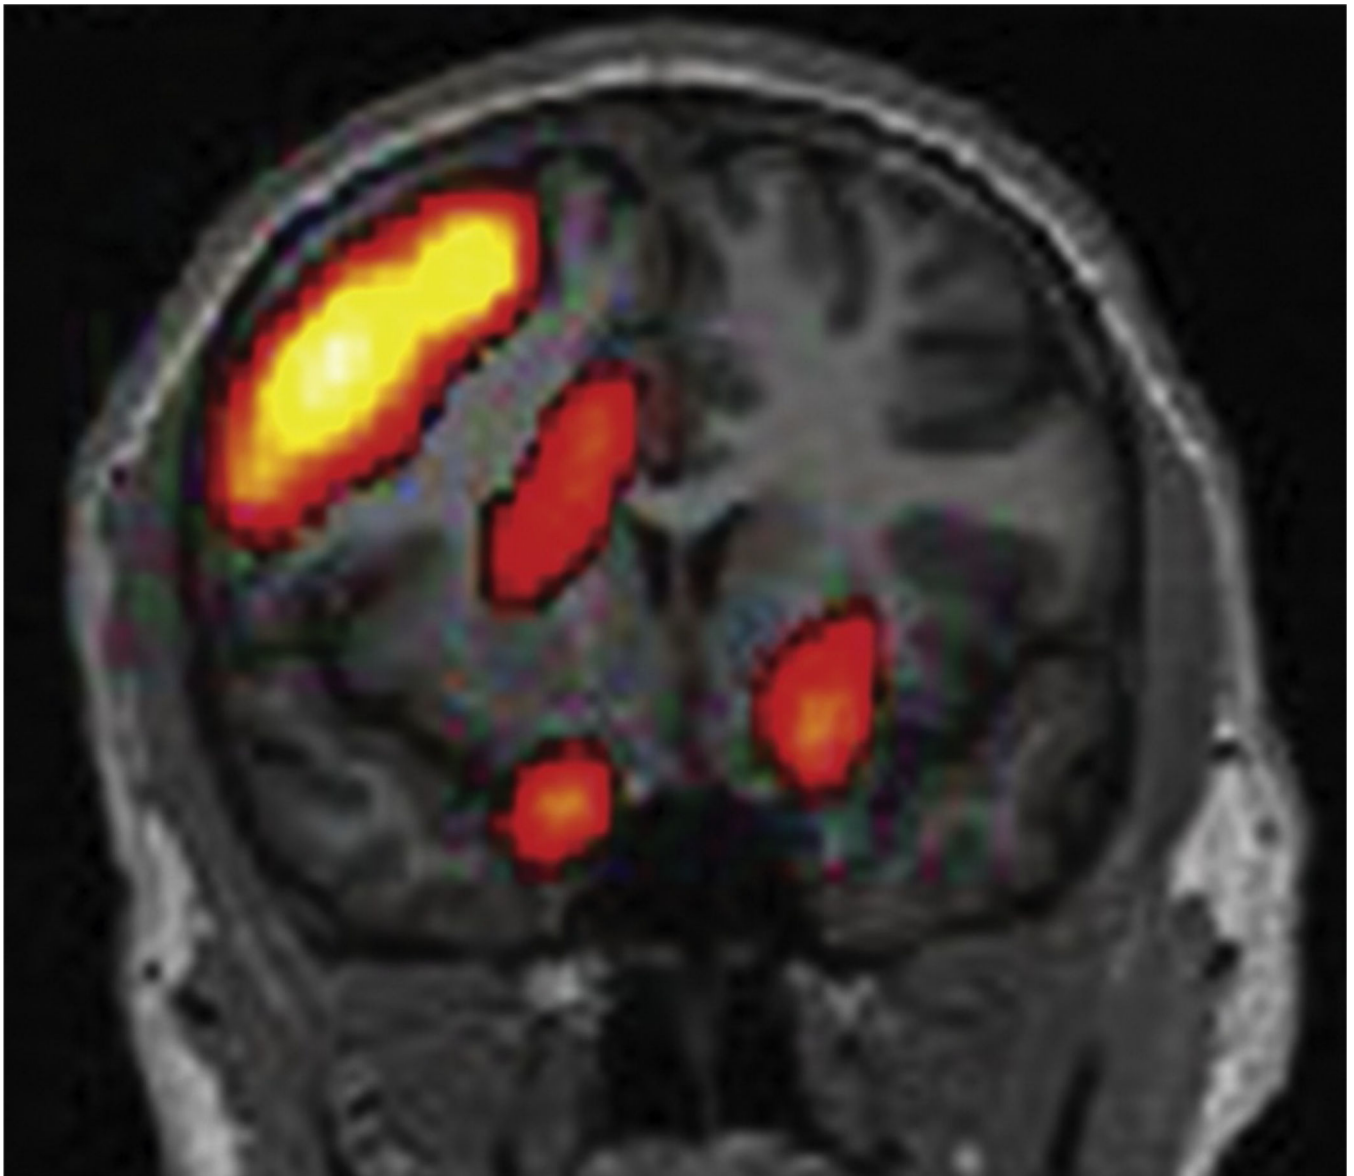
Subtraction ictal SPECT co-registered to a magnetic resonance imaging head (SISCOM) shows a region of focal hyperperfusion over the right frontal head region in a patient with nonlesional extratemporal epilepsy of right frontal-lobe origin.
